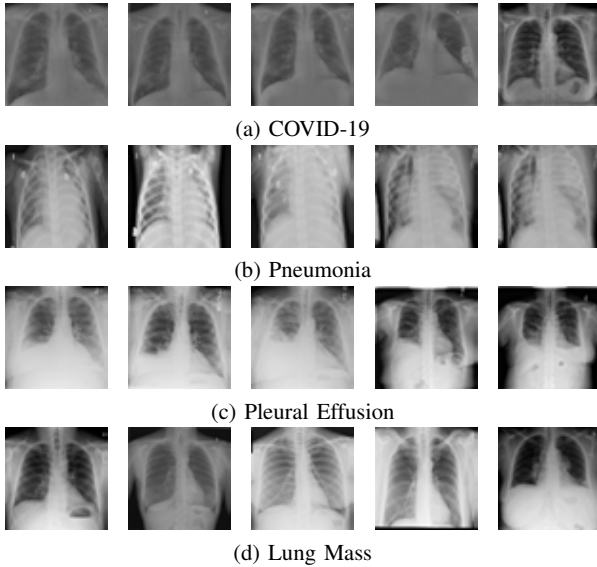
Chest radiographs showing four respiratory diseases.
